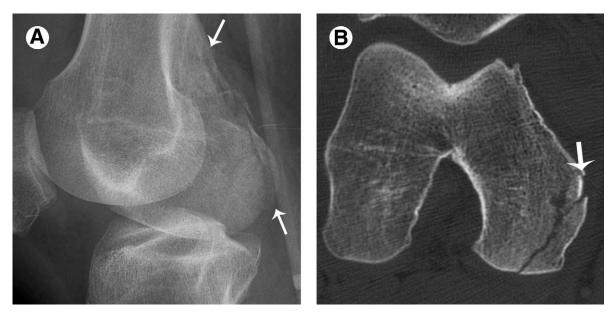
A. Oblique lateral view of the knee reveals the medial femoral condyle fracture (arrows) not seen well on AP or lateral view. B. As is typical, the CT shows that the region of MCL attachment (arrow) is involved by the fracture, but the lateral side of the MFC is not involved.
